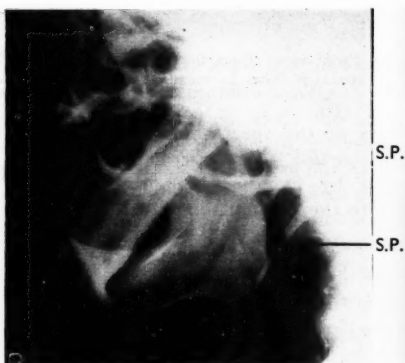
Radiograph showing elongated styloid process in apparent close relationship to the angle of the mandible. S.P., Styloid process.
